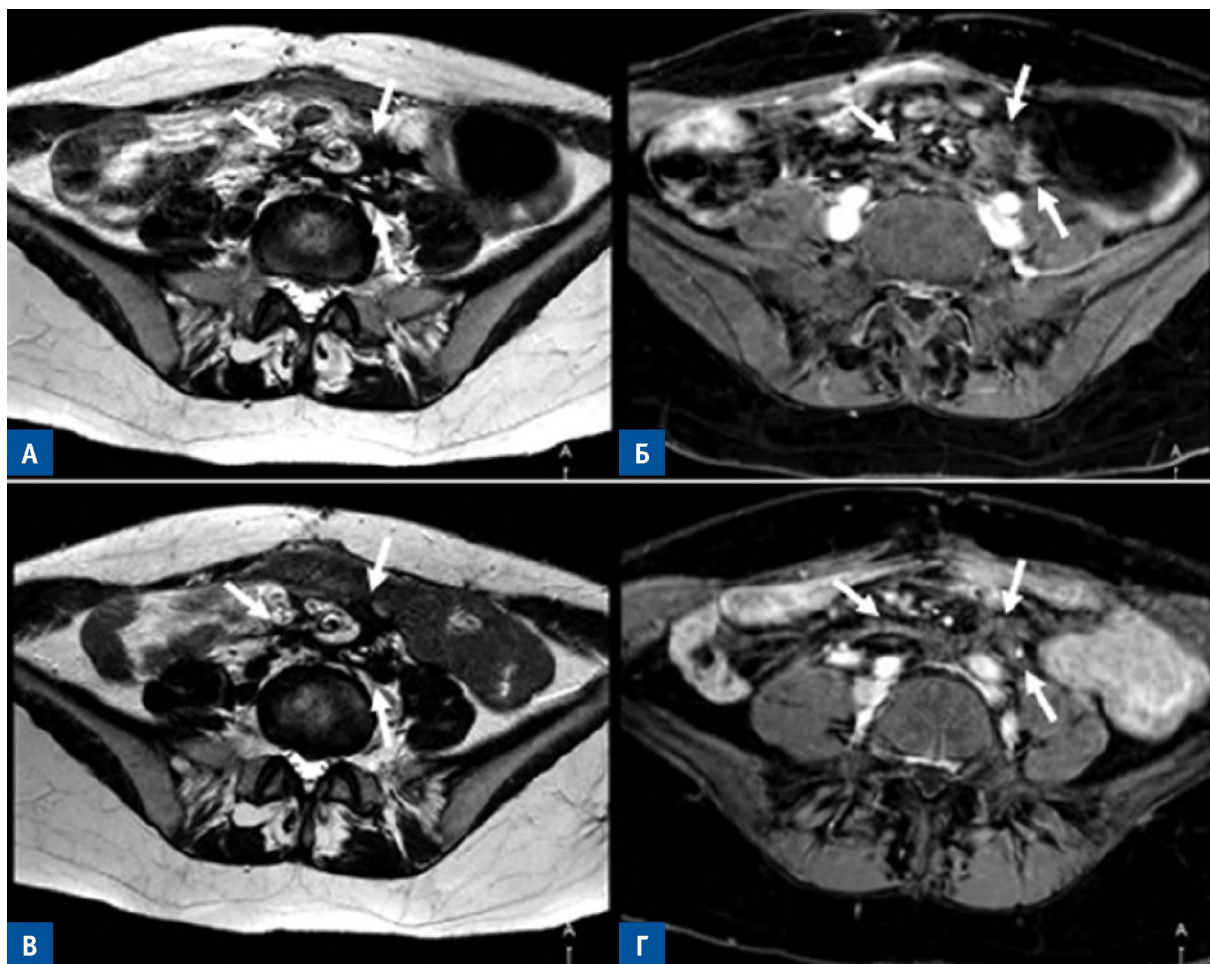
MRI with intravenous enhancement in patient D., 33 years old. Axial projections. A, B — T2-WI; Б, Г — post-contrast T1-WI with adipose suppression. Infiltrative DF of the root of the small intestine mesentery; hypointense MR signal (A) with a slight accumulation of contrast agent (Б) (arrows). When examining 12 months later, the area of the lesion, the intensity of the MR signal on T2-WI (B) and post-contrast T1-WI (Г) did not change (arrows)
